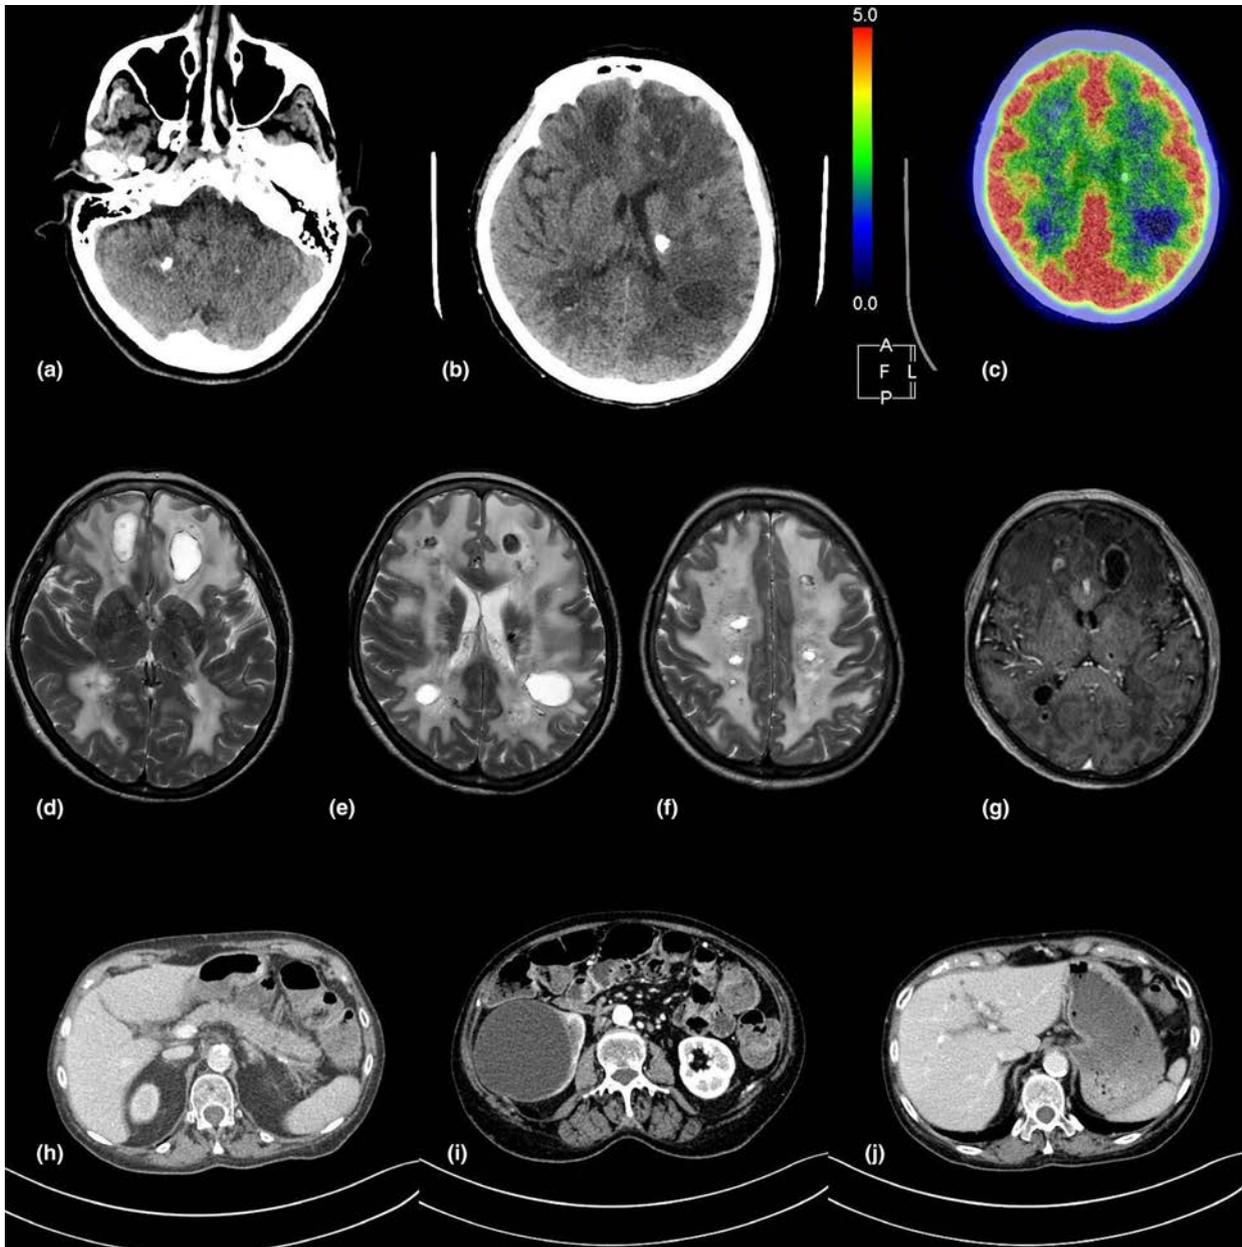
(a), (b) Non-contrast axial computed tomography (CT) images demonstrate calcifications of the bilateral dentate nuclei and left thalamus; (c) fluorodeoxyglucose positron emission tomography shows diffuse hypometabolism of the tracer, particularly in the left frontal and parietal areas; (d), (e), (f) axial T2-weighted magnetic resonance imaging (MRI) shows bilateral leukoencephalopathy in periventricular and deep white matter and multiple bilateral cysts of different sizes; (g) axial postcontrast T1-weighted MRI showing the variable degree of enhancement of the cyst wall; (h), (i), (j) axial postcontrast CT images demonstrate cysts in the liver, pancreas and right kidney
